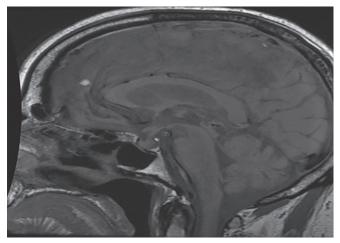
MRI brain – Enhancing lesion at sellar and suprasellar region macroadenoma/hypophysitis
